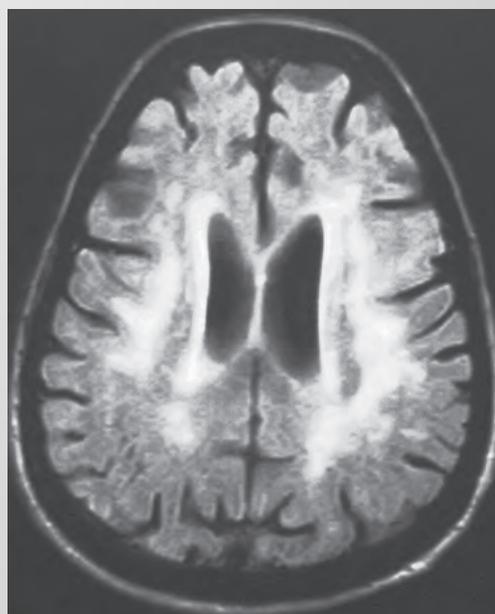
Magnetic resonance image of the head in the horizontal plane showing extensive white matter ischemic changes otherwise known as leukoaraiosis.
